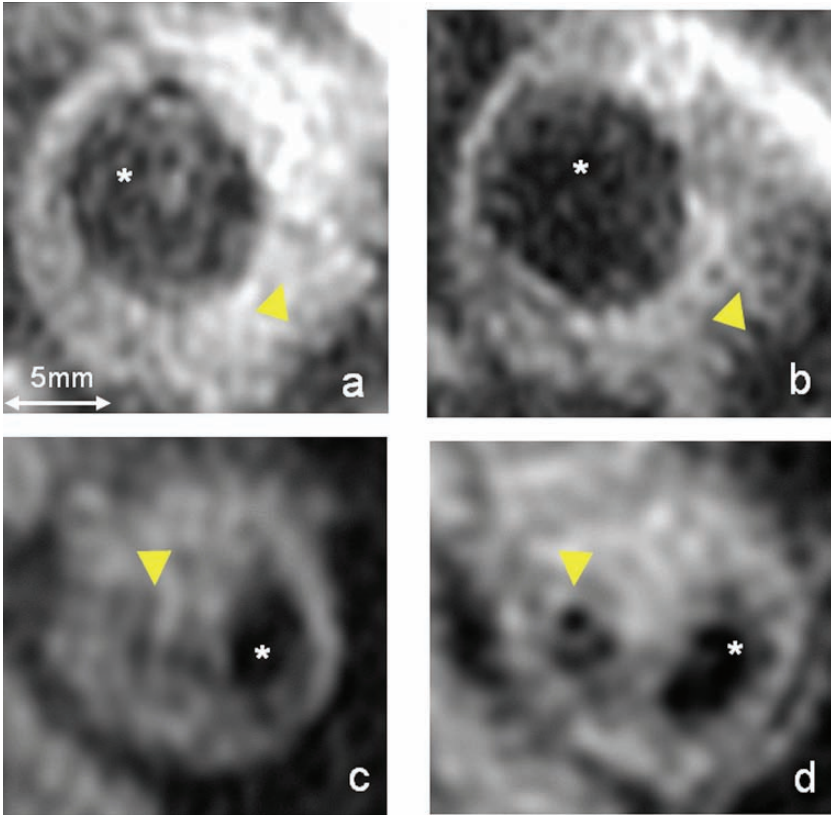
Pattern of USPIO-induced signal loss. Axial MR images (T_2^*W [TE=5.6 ms]) through the common carotid artery. a, b Diffuse USPIO effect. c, d Focal USPIO signal effect. a, c Pre-USPIO images. b, d Thirty-six hours after infusion (*lumen, arrow heads: USPIO signal effect). Images provided by courtesy of Gillard. Reprinted from Trivedi et al. (2006), with permission of Lippincott Williams & Wilkins.
